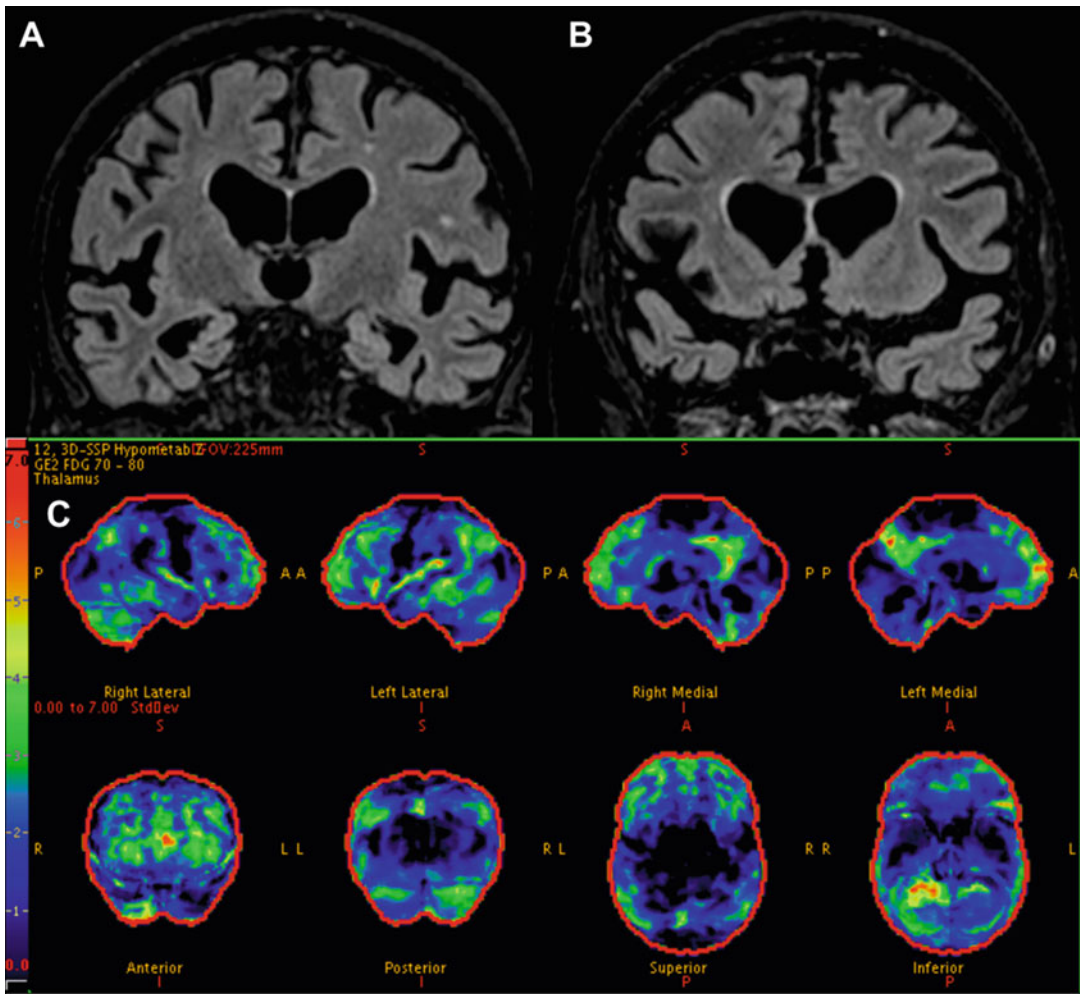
Coronal reconstructed FLAIR (a) demonstrates significant hippocampal atrophy MTA 3 in a 78 years old man. To a lesser degree, there is associated frontal and anterior temporal atrophy (b). There is only minor white matter disease Fazekas 1. Parametric FDG PET (c)
